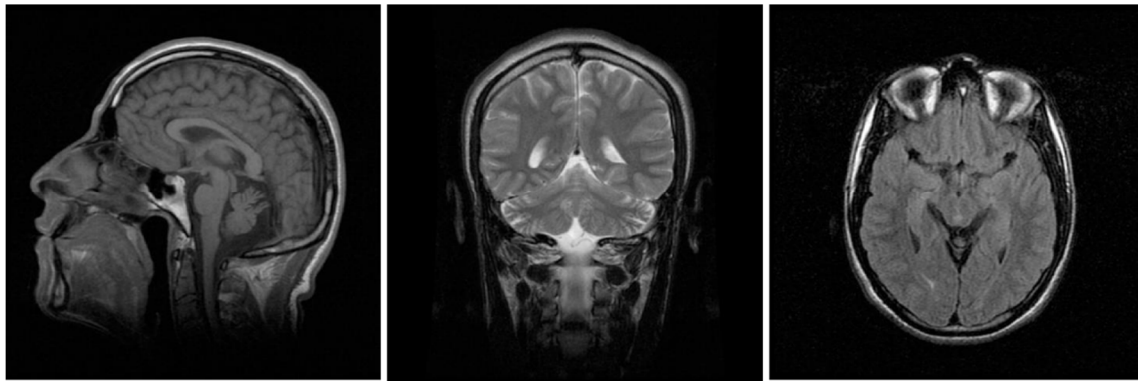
Brain MRI of male proband at 22 years of age. Sagittal (left panel), coronal (middle panel) and axial (right panel) sections of T1-weighted images are shown. Hypoplasia of the posterior and nodular regions of the cerebellar vermis, but not of the hemispheres, are evident. Axial FLAIR section shows no evident abnormalities of the white matter.
